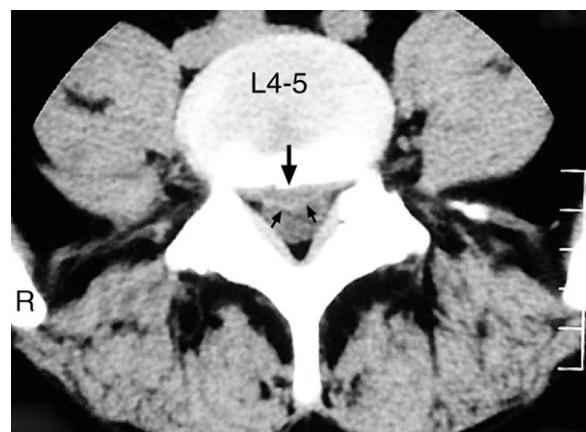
Lumbar spine CT axial image at the L4–5 level. Note: (i) the median disc protrusion (large black arrow) abutting the left and right nerve roots and indenting the dural tube anteriorly (small black arrows). R = right side of patient.
